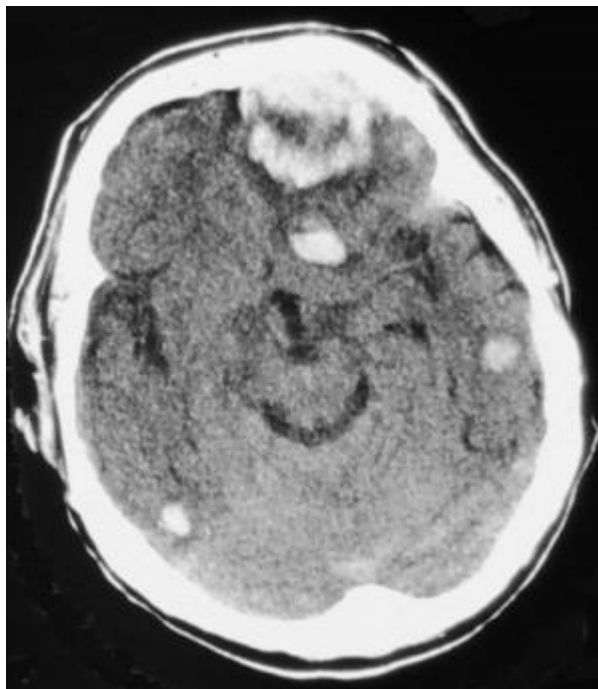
CT appearance of cerebral contusions
